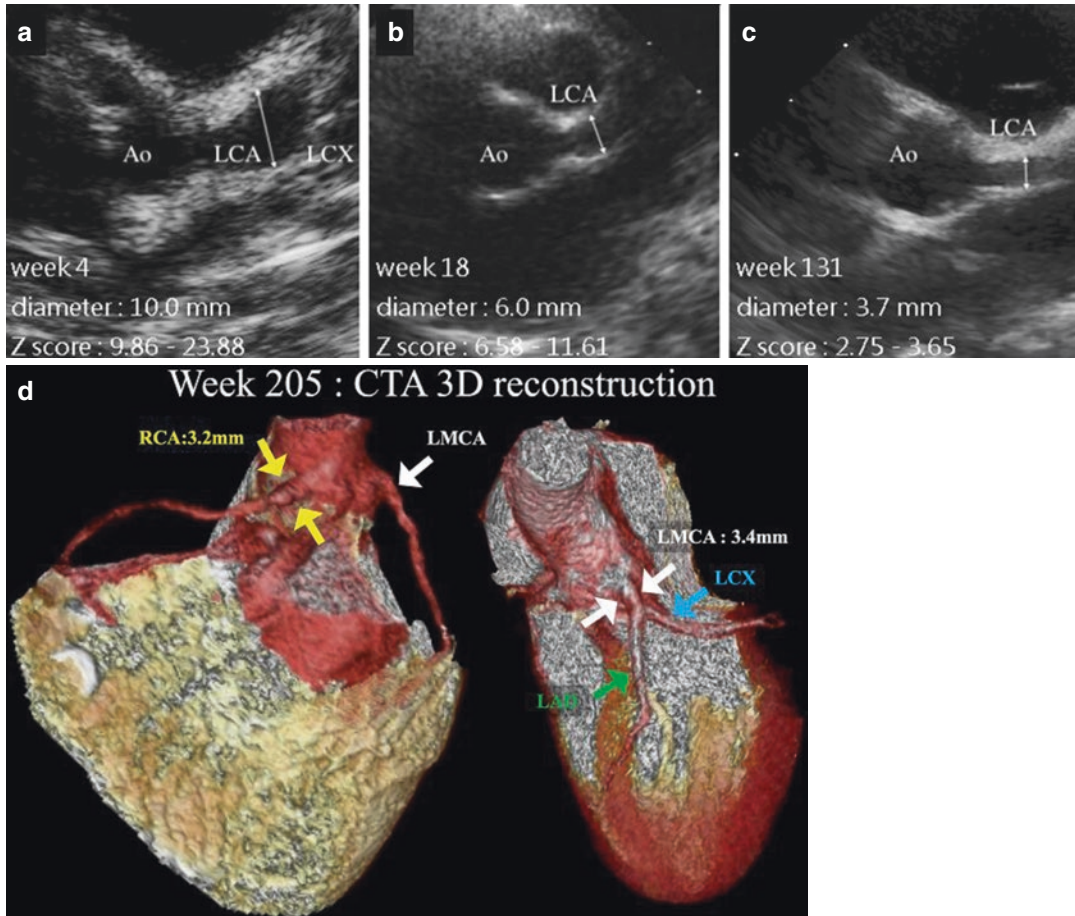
Regression of the giant aneurysms validated by TTE and CTA. (a–c) TTE imaging showed coronary luminal dimension regression in week 131, (d) the 256-slice, three-dimensional reconstruction coronary CTA imaging
